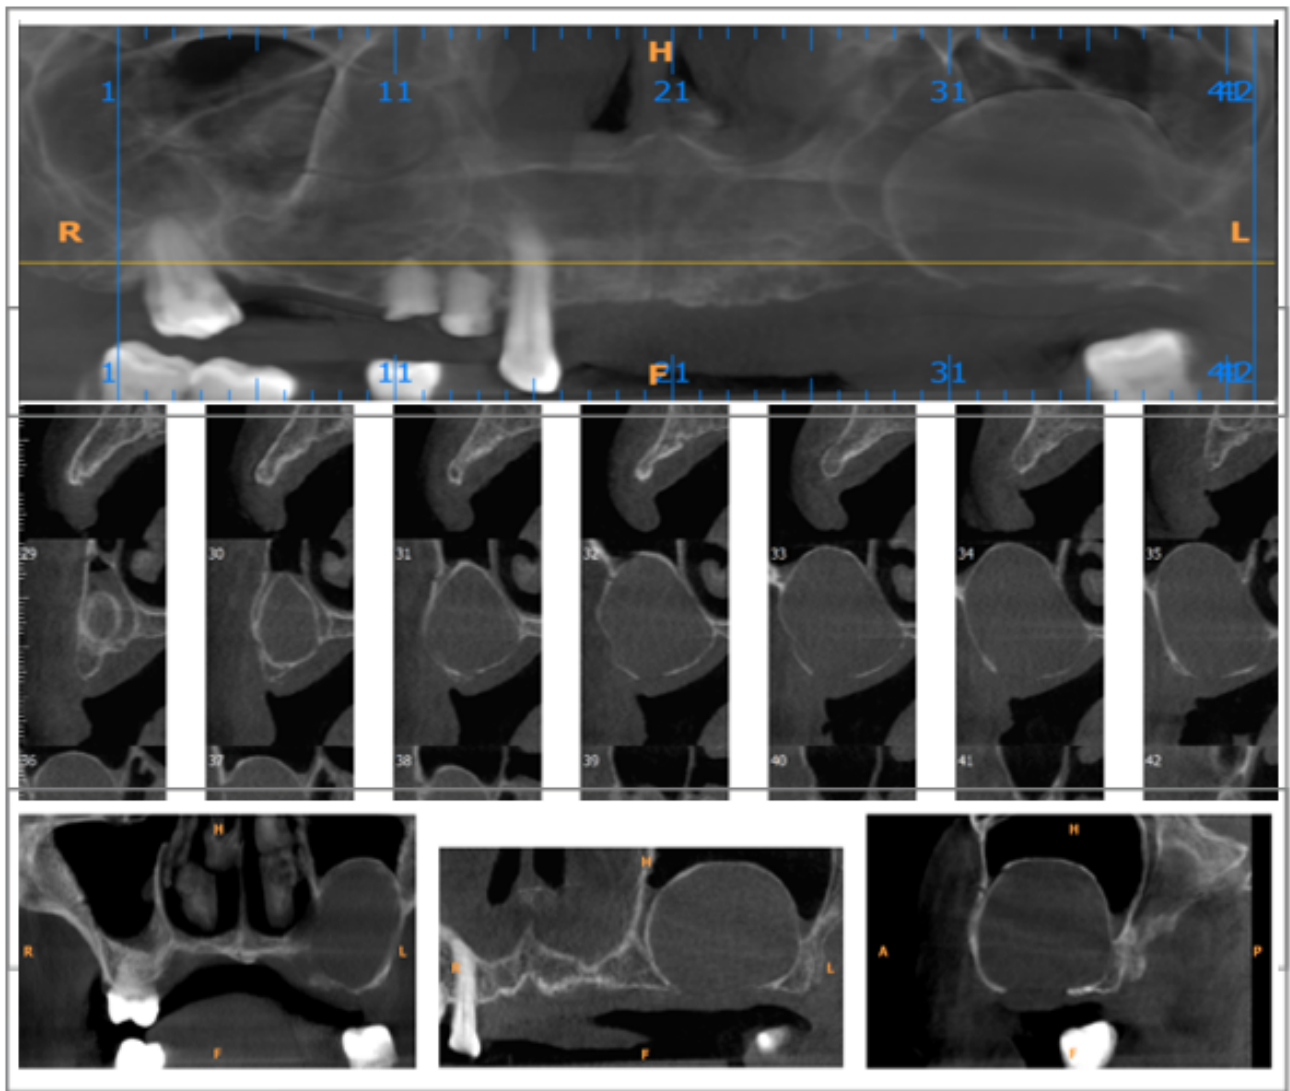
CBCT sections showing unilocular hyperdense area in maxillary sinus encroaching and obliterating it except superior aspect.
